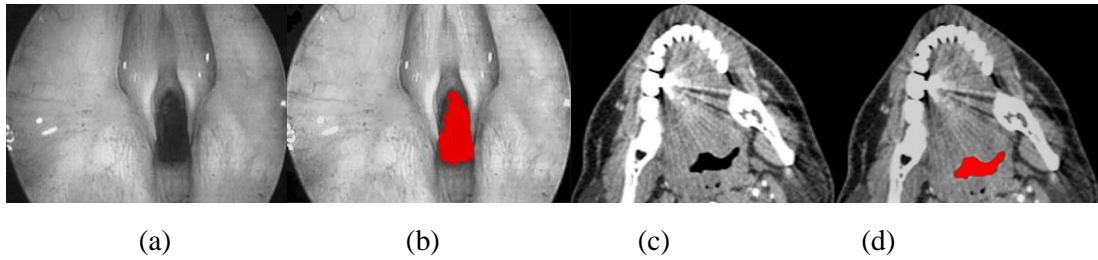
Endoscopic image (a) before and (b) after IIIH reduction and detection of a trachea. CT image (c) before and (d) after IIIH reduction and detection of a throat region This Figure shows application of IIIH reduction algorithm and ThDA for dataset other than MRI.
